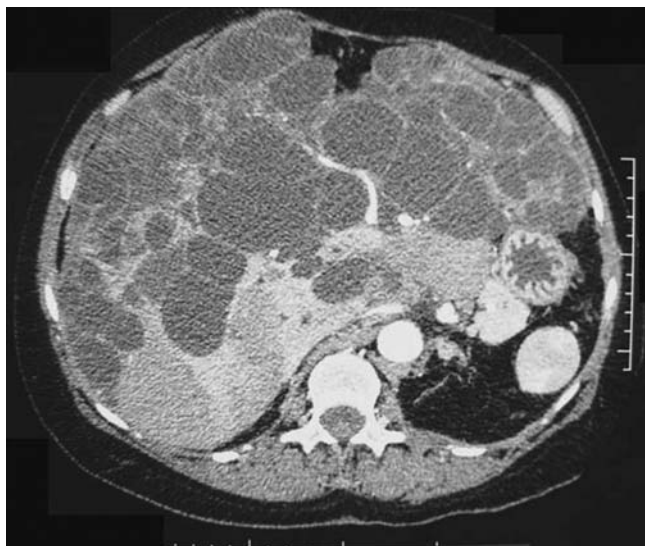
CT demonstrating polycystic liver disease (PCLD).
